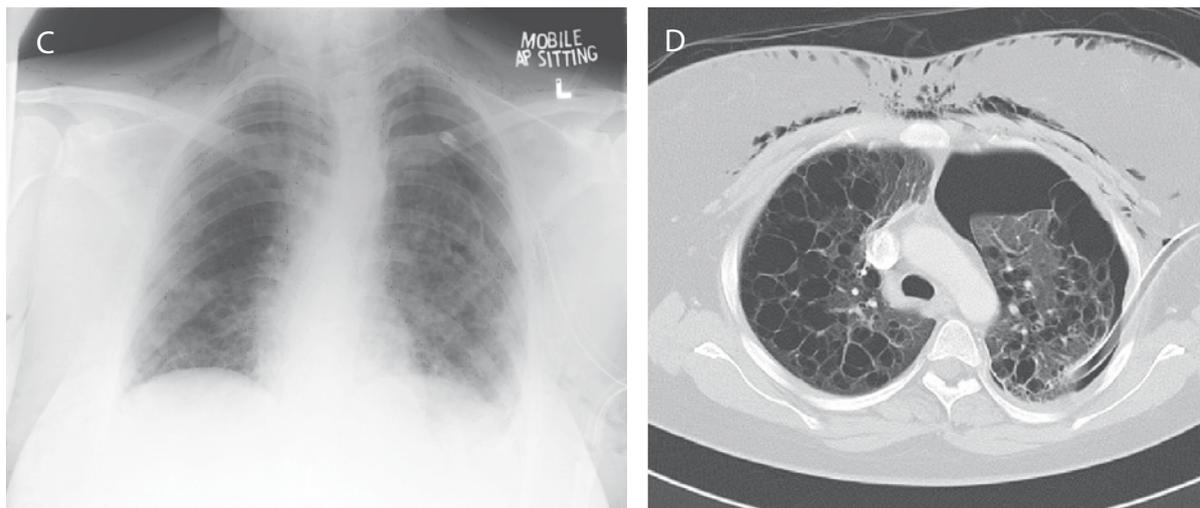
CXR (C) and HRCT thorax (D) of the patient showing extensive cystic lesions of the lungs
